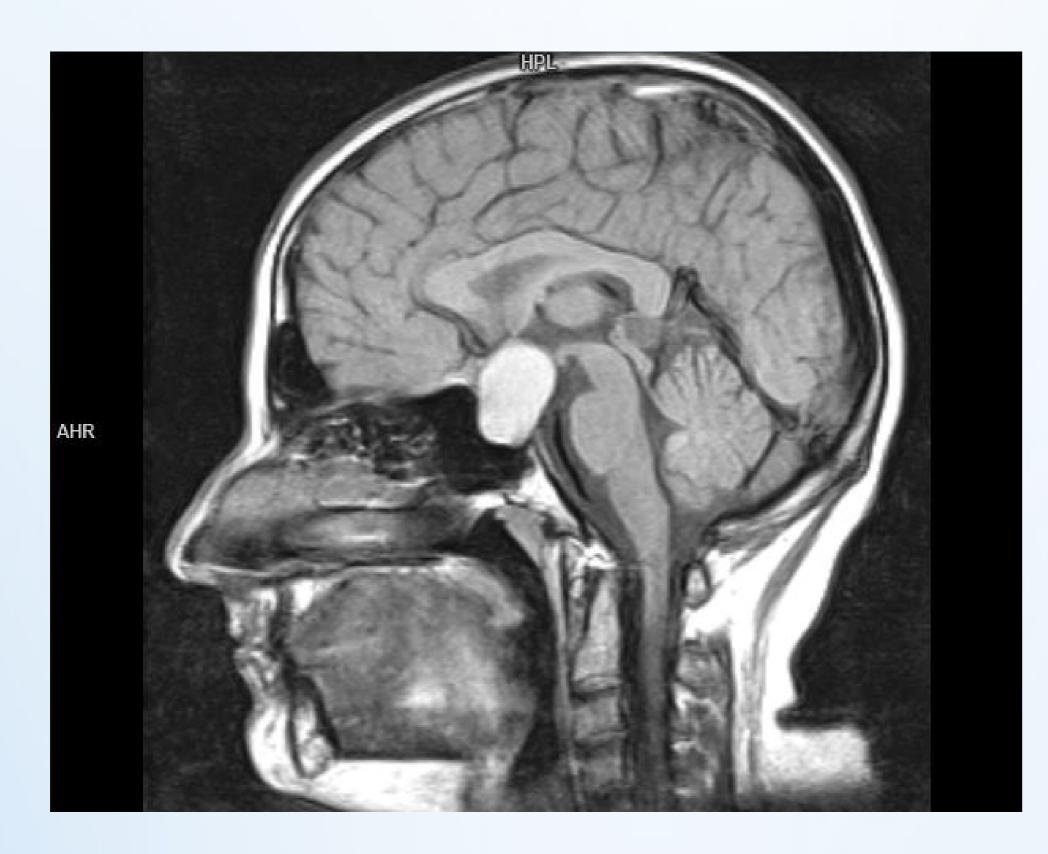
MRI image of patient with Rathke Cleft Cyst
